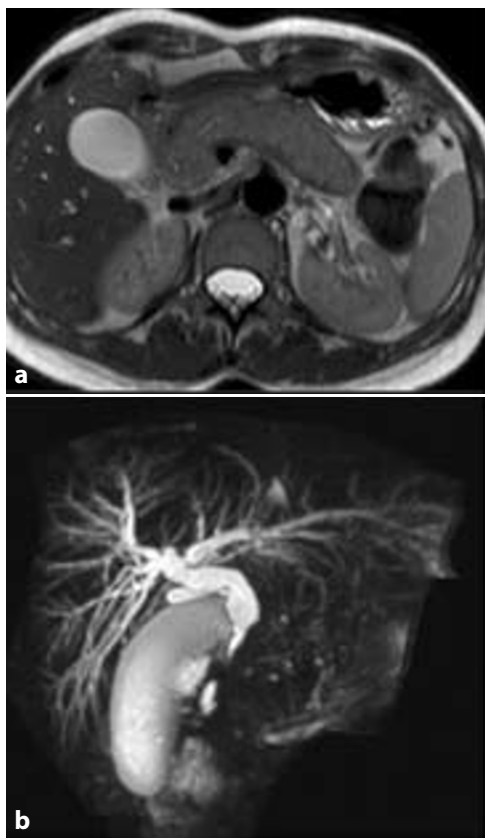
MRI findings of a patient suffering from the diffuse form of autoimmune pancreatitis. a The axial sequence shows a diffuse enlargement of the pancreas, with a peripheral rim. b MRCP shows a stenosis of the intrapancreatic segment of the common bile duct with upstream dilation of the extra- and intra-hepatic trees, without dilation of the main pancreatic duct
